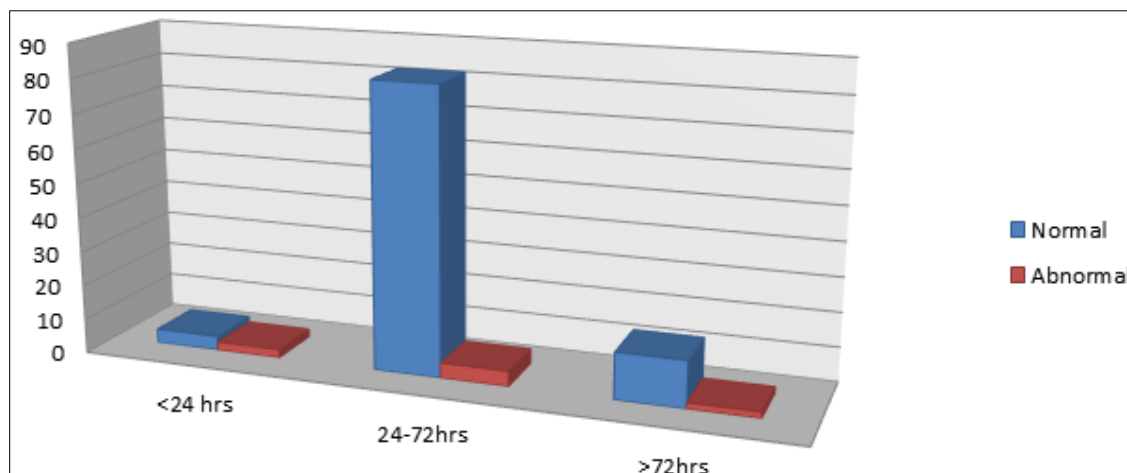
Bar chart showing distribution of high risk Neonates based on timing of cranial ultrasound
